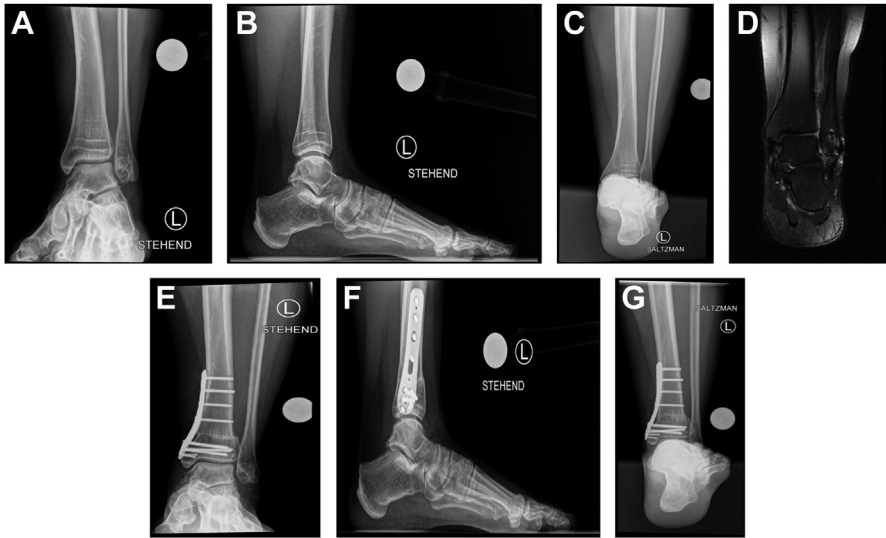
Case of Joint Preserving Surgery (JPS) by Supramalleolar Osteotomy of the Tibia (SMOT) for Valgus Ankle Osteoarthritis. Preoperative weight-bearing AP (A) and lateral (B) radiographs of the ankle and Saltzman view (C) demonstrating valgus ankle deformity, posttraumatic chronic painful lateral ankle cartilage degeneration (D) with a lateral osteochondral lesion (OCL) of the talus with medial and lateral chronic ankle instability and pes valgus. Postoperative weight-bearing AP (E) and lateral (F) radiographs of the ankle and Saltzman view (G) after the following surgeries: diagnostic ankle arthroscopy, debridement and abrasion of the lateral talus OCL, supramalleolar medial closing tibial osteotomy SMOT (Anatomic APTUS Medial Supramalleolar Tibia Osteotomy Plate, Medartis, Switzerland), medial ankle ligament surgery, and lateral ankle ligament surgery with an ipsilateral semitendinosus tendon graft.
